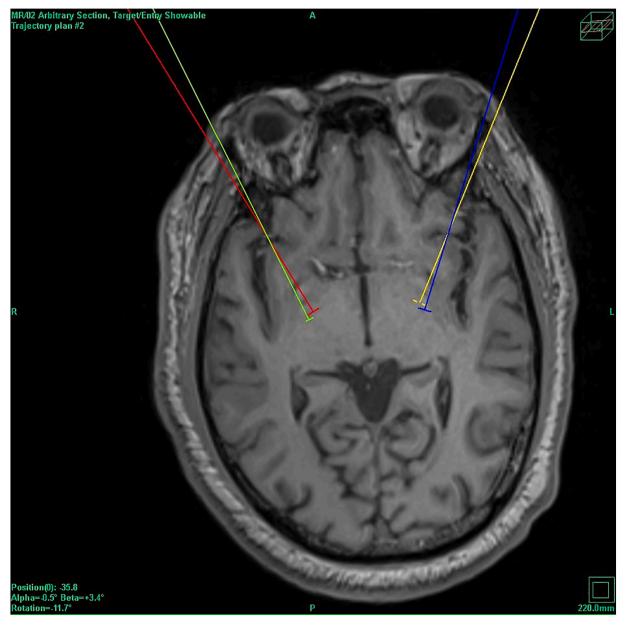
Target set for GPI Pallidotomy in IPS software. Axial MRI Image.
